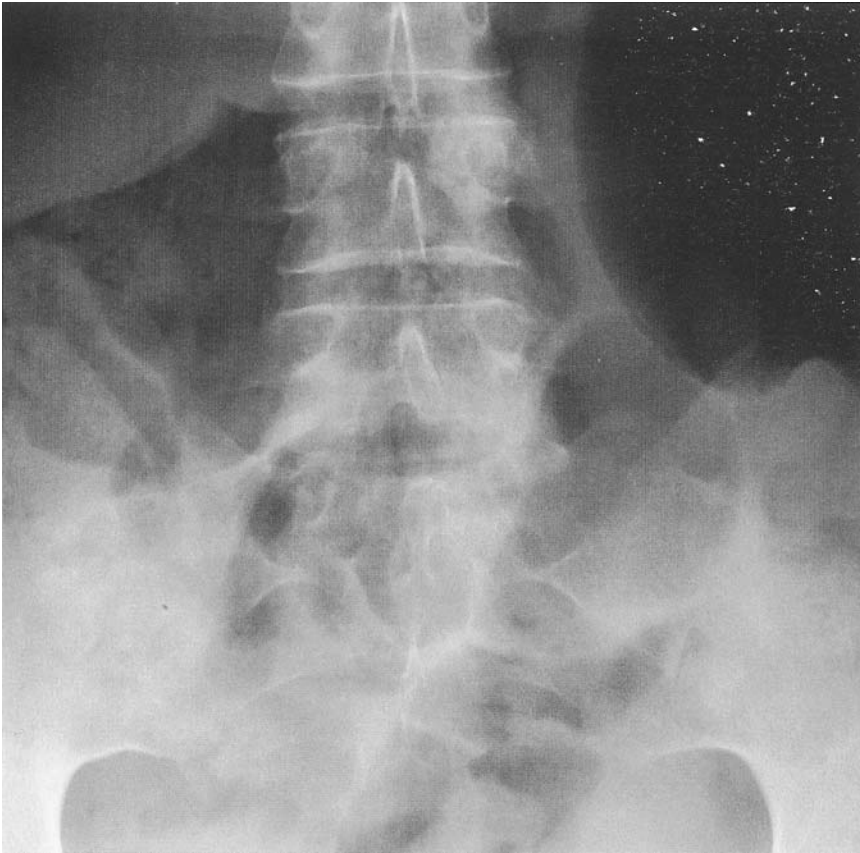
Plain film demonstrates early fusion and sclerosis of the sacroiliac joints.
